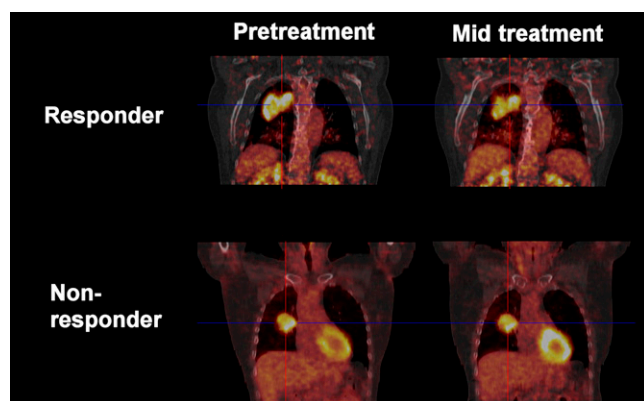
Patient example of metabolic responder vs. nonresponder for both pretreatment and mid-treatment ¹⁸F-FDG PET/CT. SUV window levels are scaled equally per patient.
